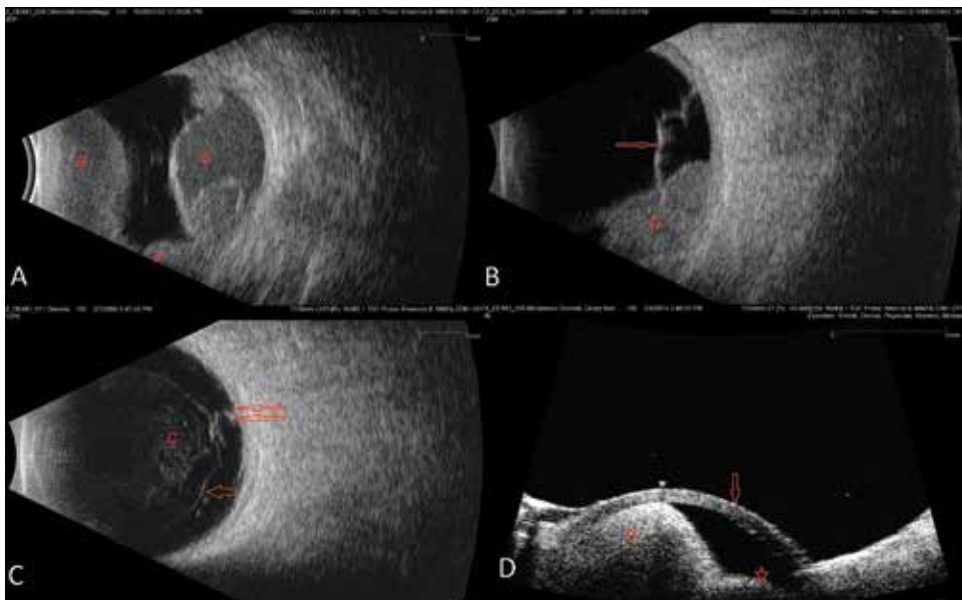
Examples of images from B-scan ultrasound. (A) An image of choroidal hemorrhage. Areas of hemorrhage indicated by (a). (B) Choroidal melanoma (b) with associated superior retinal detachment (arrow). (C) A diabetic patient with vitreous retinal traction. Area of vitreous hemorrhage shown by (c); single arrow indicates posterior hyaloid membrane; double arrow shows point of fibrovascular adhesion. (D) Ciliary melanoma (d) invading into the anterior chamber; arrow indicates cornea while star shows the location of the iris. Images used courtesy of Ellex.
